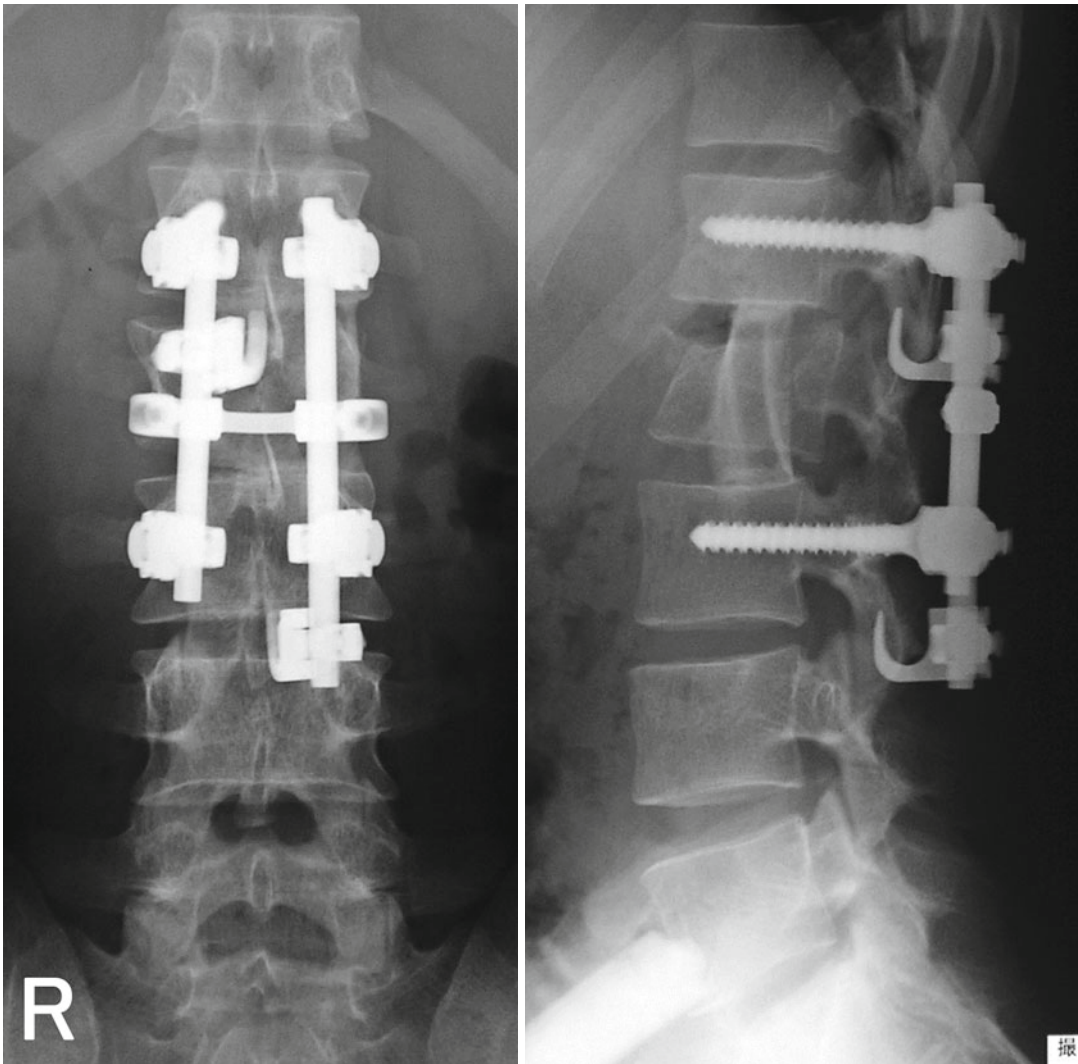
Postoperative AP and lateral X-rays
